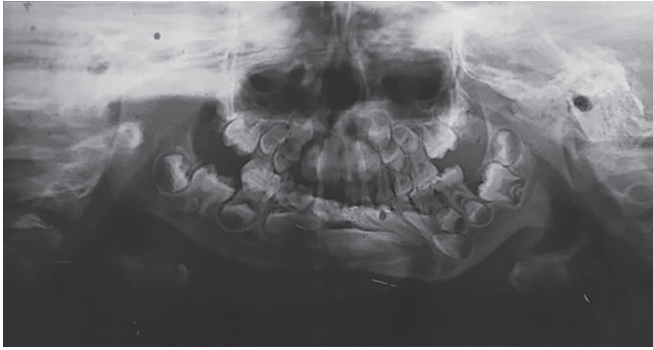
Preoperative orthopantomogram showing bilateral mandibular fractures
